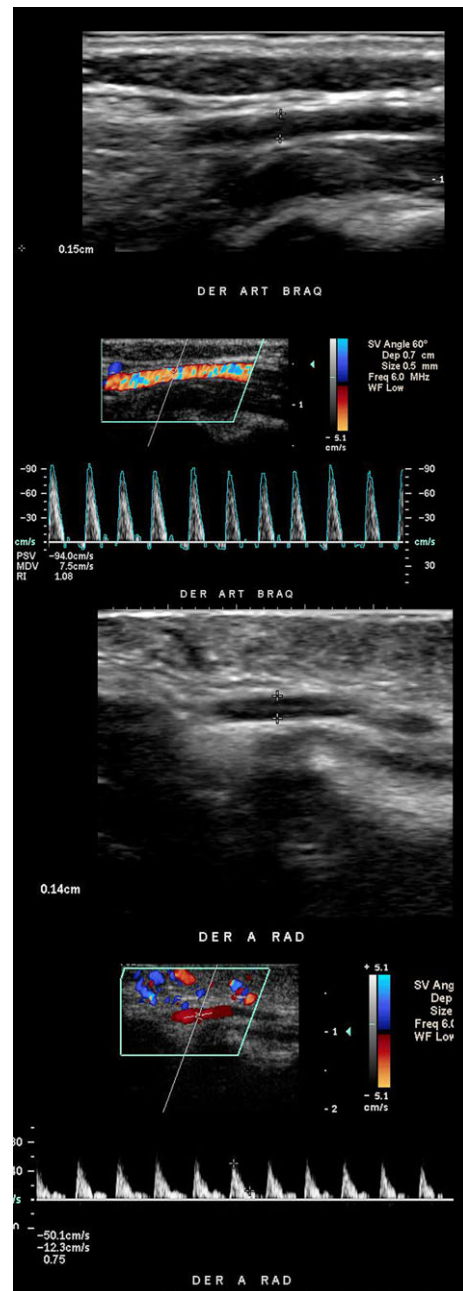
Sonographic measurements of maximum thickness and arterial peak systolic velocity of the brachial and radial arteries (gray scale and color Doppler ultrasound spectral curve analysis).
